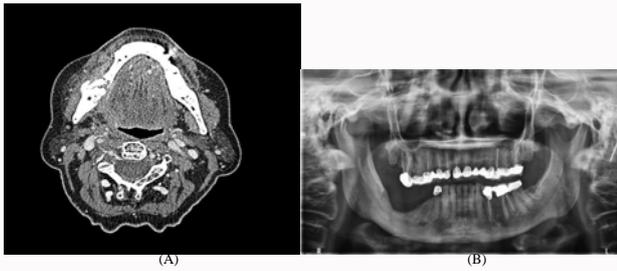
A) CT scan image revealed ill-defined bony changes with osteolytic and osteosclerotic areas associated with a pathological fracture of the right body of the lower jaw (red arrow). B) Post operative panoramic X-ray shows full recovery of the patient with optimum bone healing of the fracture of the lower right jaw.
